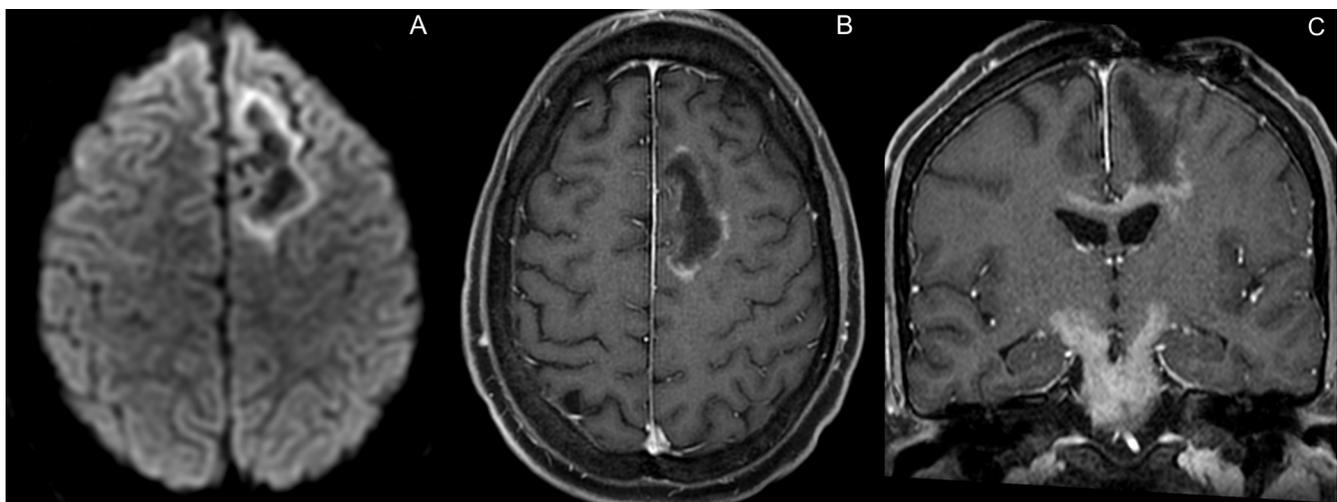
Control MRI two months later, demonstrates persistent restricted diffusion (A), but less enhancement of the left frontal lesion (B). C (coronal post-gadolinium T1): Its caudal aspect extends and invades the corpus callosum. Notice the development of a new and solid-enhancing lesion on the brainstem, extending along the cerebral peduncles and the postoperative changes on the left frontal lobe.
